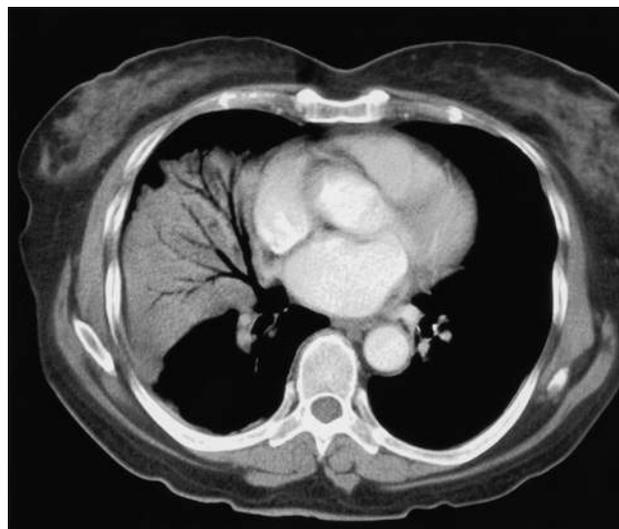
Right middle lobe pneumonia. Computed tomography slice shows an alveolar filling process in the right middle lobe with tubular air bronchograms running through it. The patient is a 73-year-old woman with right middle lobe pneumonia.
